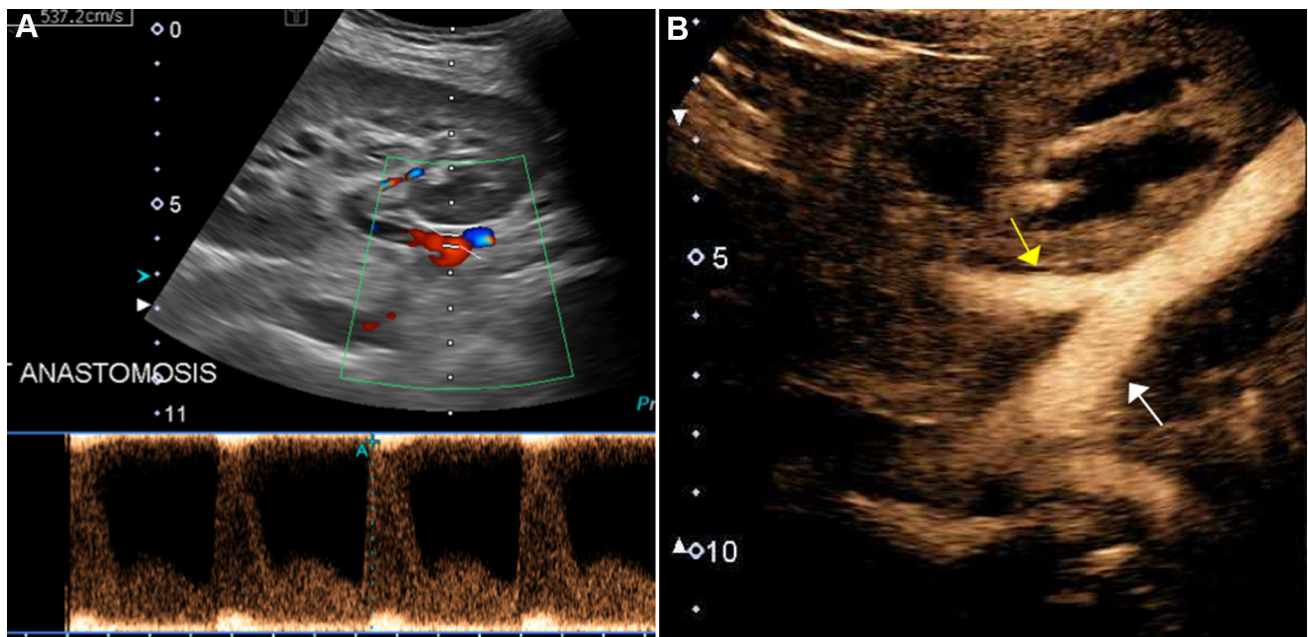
A 26-year-old male with history of right iliac fossa renal transplant 2 months prior presenting for routine sonographic follow-up. A Spectral Doppler evaluation of the transplant kidney demonstrates elevated velocity at the renal artery anastomosis. B CEUS of the renal artery anastomosis
